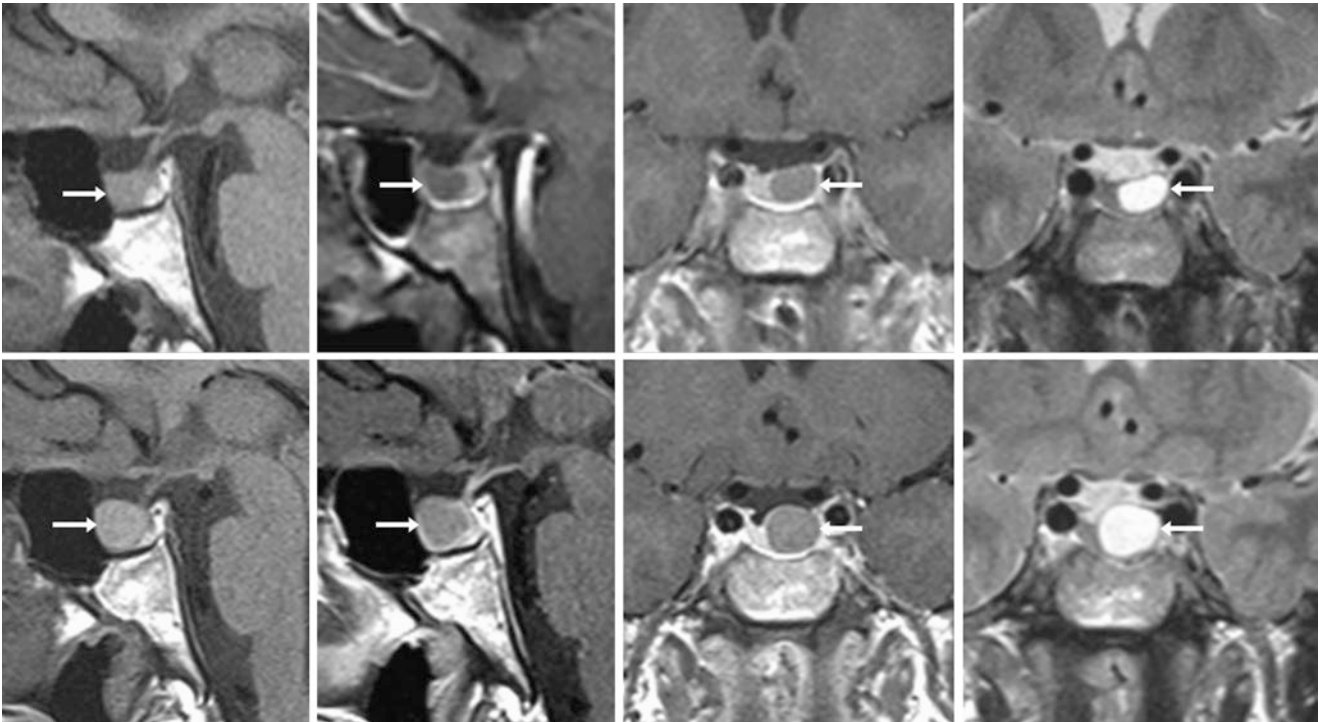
The patient was a 27-year-old male with retro-orbital pain. A 1.5 T MRI noted a 10×9 mm RCC (*arrows*) on sagittal precontrast (*top left*) and postcontrast (*top, left middle*) T1WIs, on coronal postcontrast T1WI (*top, right middle*), and on T2WI (*top right*). An MRI 7 years
